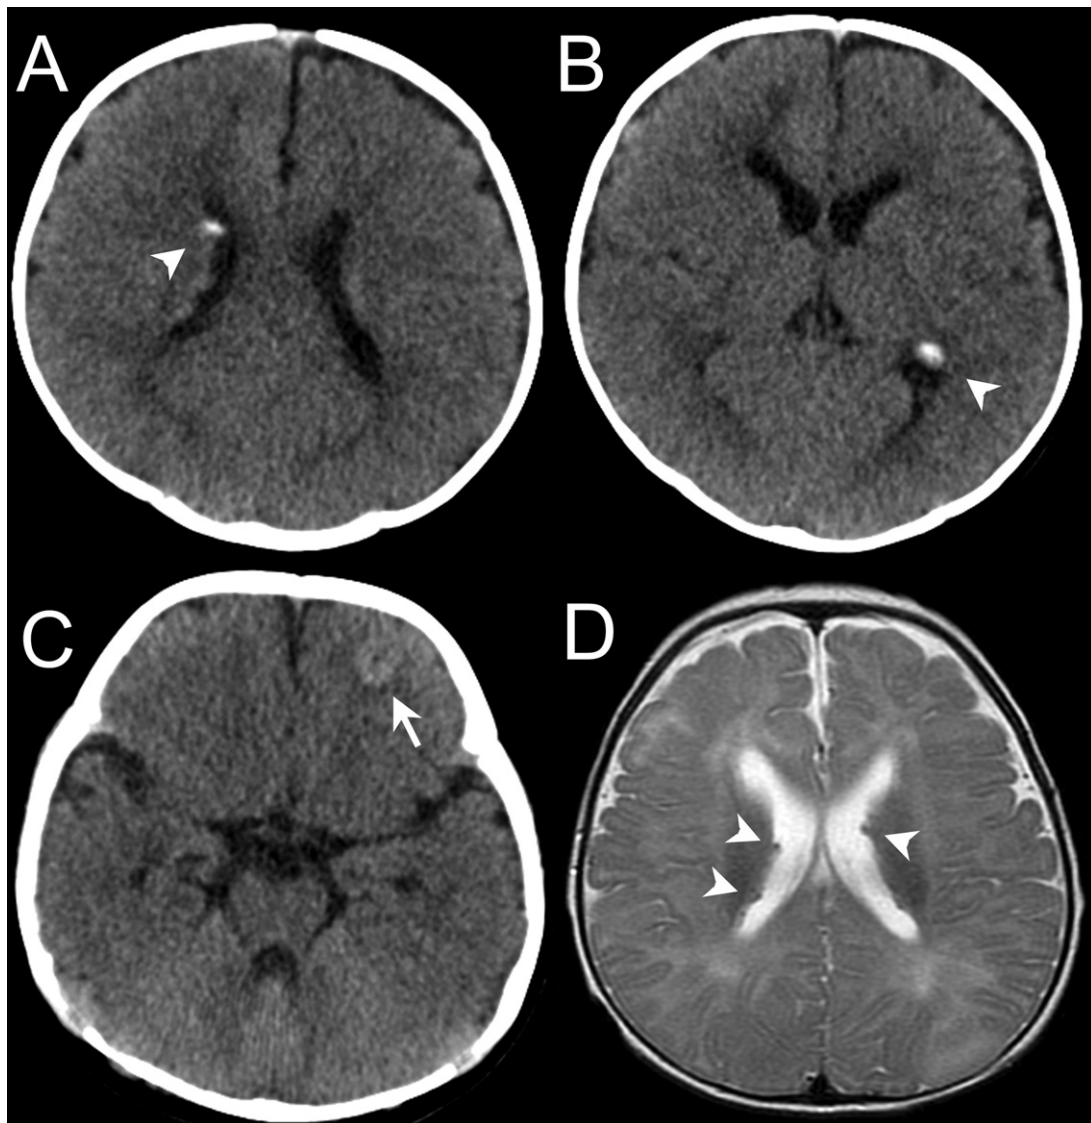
Brain CT shows calcified subependymal nodules (arrow heads) in the walls of both lateral ventricles (A, B) and an area with a high density of cortical tubers (arrow), 1 cm in diameter, in the left frontal lobe (C). Several low-intensity nodular lesions (arrow heads) suggesting subependymal nodules are seen along the walls of both lateral ventricles on T2-weighted MRI (D).
